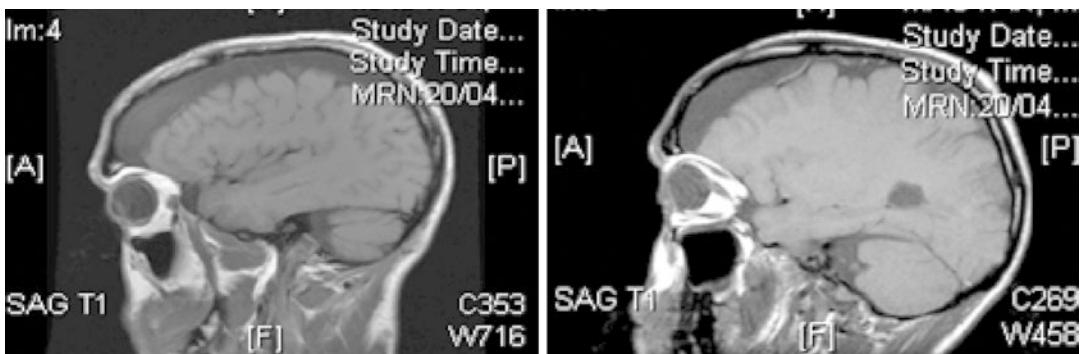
Sagittal MRI shows large subdural hygromas bilaterally. Hypothesized etiology is that slowly evolving subdural hematomas formed following the 1985 injury.
